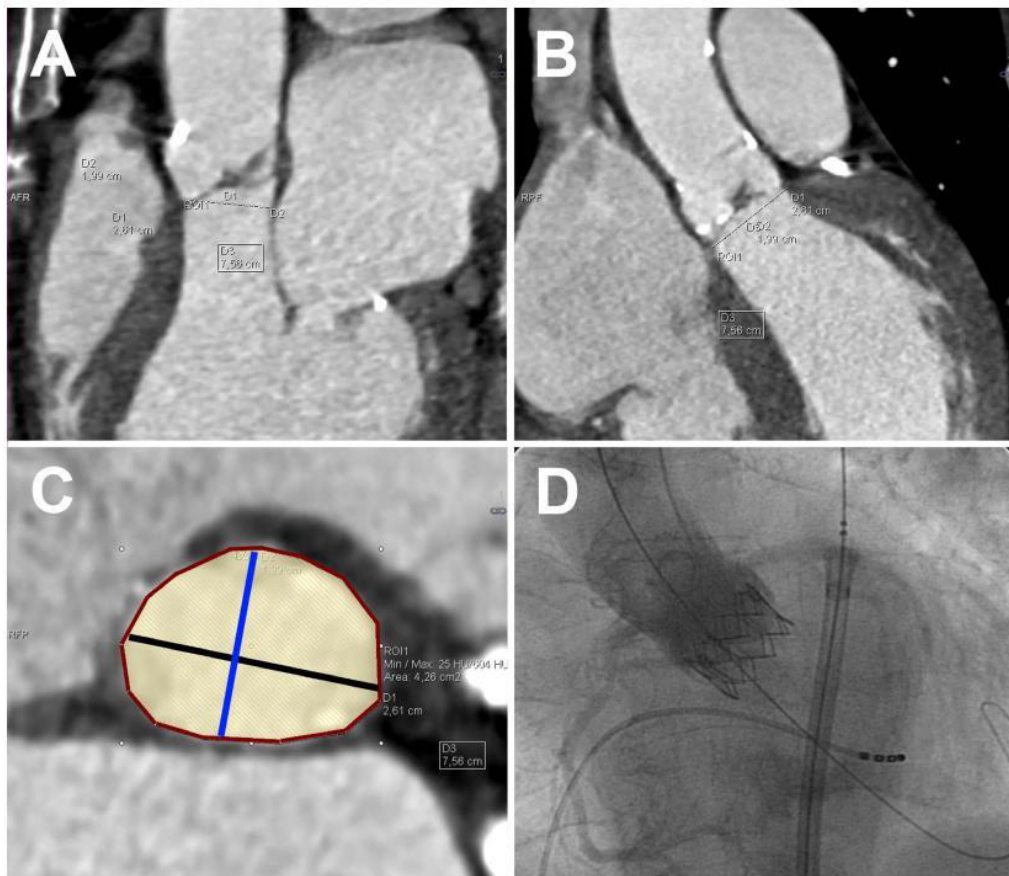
Examples of anatomic measurements at the aortic annulus performed for this study: isotropic small field-of-view CTA dataset of a 78 year old female patient with severe aortic stenosis, A) sagittal reformation and B) coronal reformation showing the orientation of the aortic annulus plane, C) double-oblique reformation of the aortic valve annulus, demonstrating the diameter of the long axis (black line), the diameter of the short axis (blue line), the annulus circumference (red polygonal), and annulus area (yellow shading). D) angiographic image after implantation of a 26 mm model of the Edward Sapien XT valve prosthesis demonstrates no paravalvular leakage.
